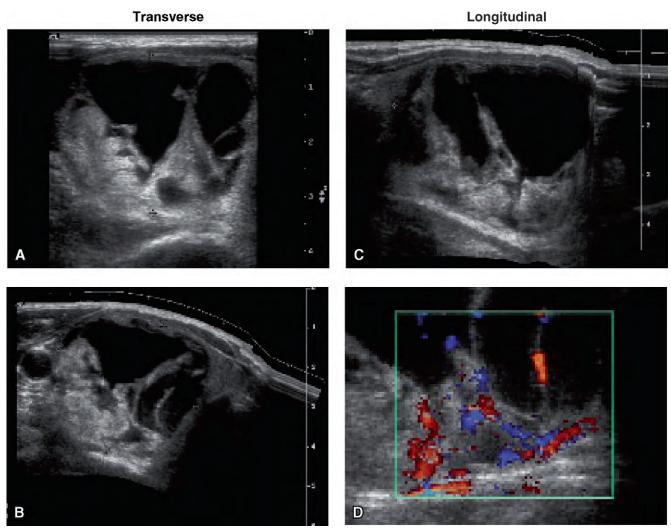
Ultrasound of a colloid nodule in the right lobe. A, Transverse, 35×38 mm. B, Transverse. C, Longitudinal, sagittal diameter: 40 mm. D, Color Doppler, longitudinal.
